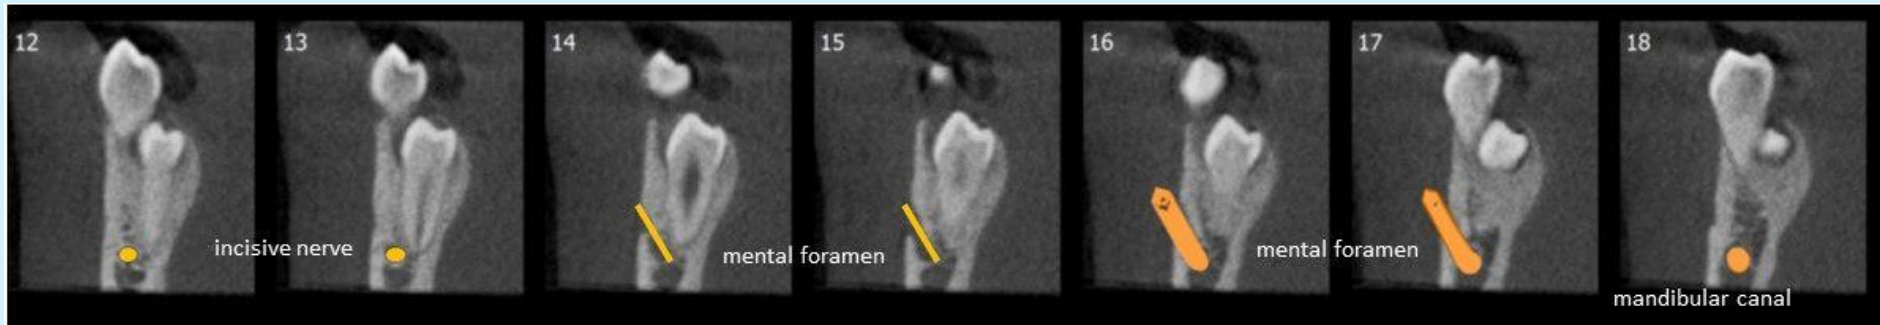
CBCT image-cross sections
